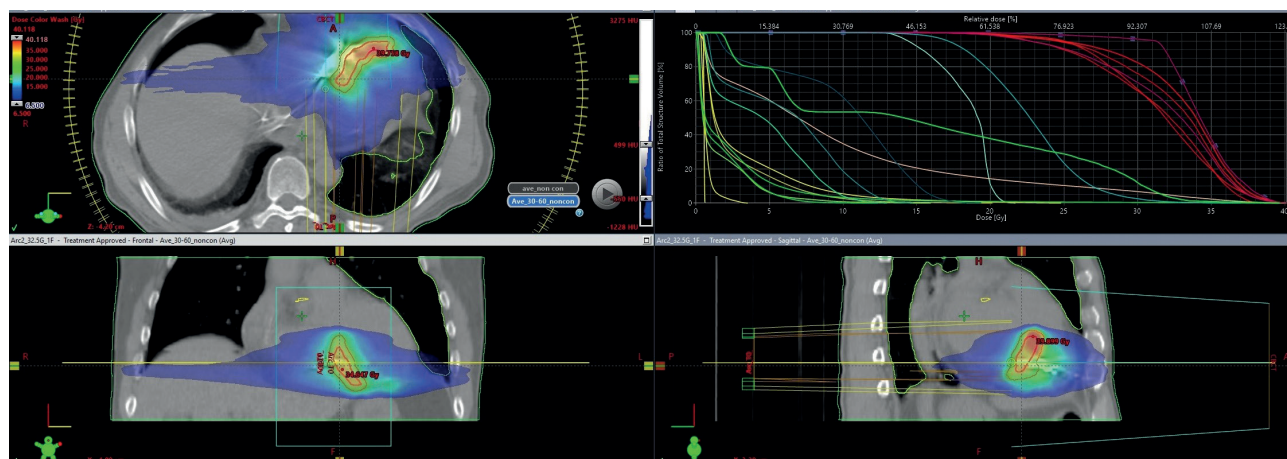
Dose distribution visualisation, projection of the target area in segments 1416 of the left ventricle onto native cardiac CT of a patient in the Eclipse treatment planning system.
